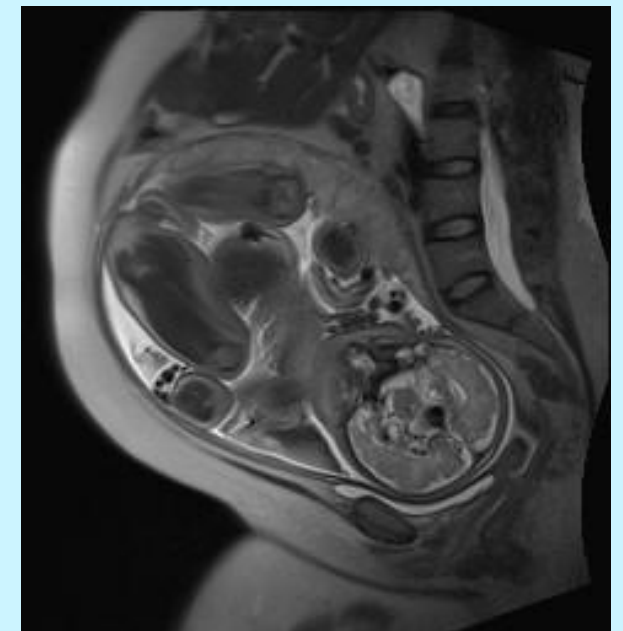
MRI abdomen in pregnancy⁴
